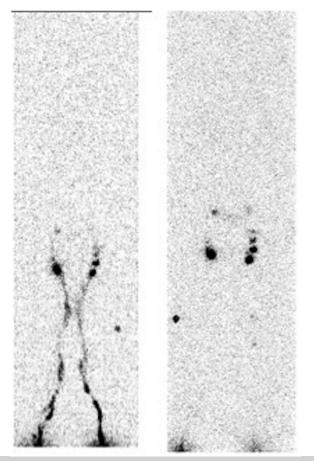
Right, Lymphoscintigraphy of the lower limbs at 10 minutes postoperatively. Left, Lymphoscintigraphy of the lower limbs at 4 hours postoperatively.
